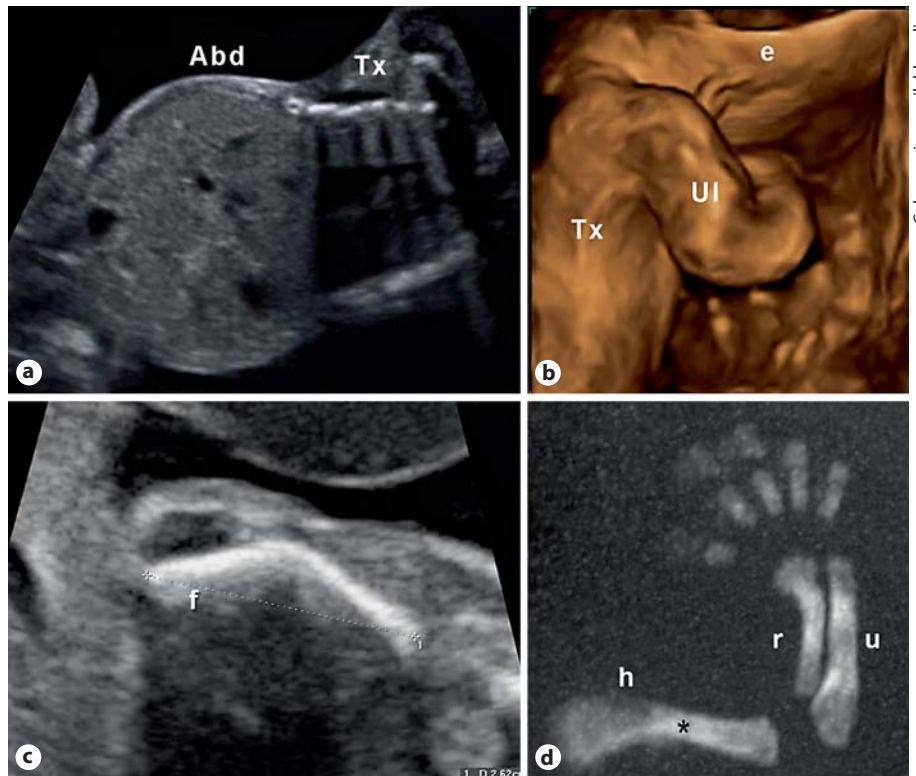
Case 4: osteogenesis imperfecta type II. Abd = Abdomen; Tx = thorax; Ul = upper limb; e = ear; h = humerus; u = ulna; r = radius; f = femur. a Prenatal 2D-US: narrow thorax. b Prenatal 3D-US: bowing of the right upper limb. c Prenatal 2D-US: bowing of the femur. d Prenatal 3D-CT: shortening and bowing of the upper limb. Note also the humeral fracture (*).
